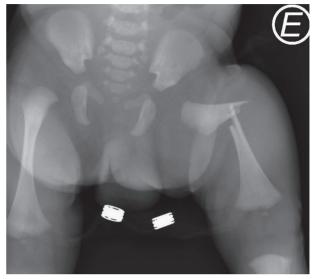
Femur radiography performed on the first day of life showing a diaphyseal fracture of the left femur.
